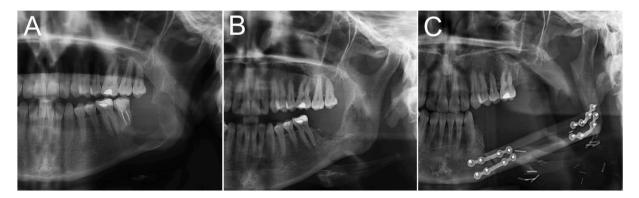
Panoramic radiographs from A) 2018 before the second enucleation showing a multilocular radiolucency in the left angle of the mandible. B) 2019 before resection. Some bone ingrowth is seen despite the growing soft tissue mass. C) After resection and reconstruction with a free vascularized fibula flap.
